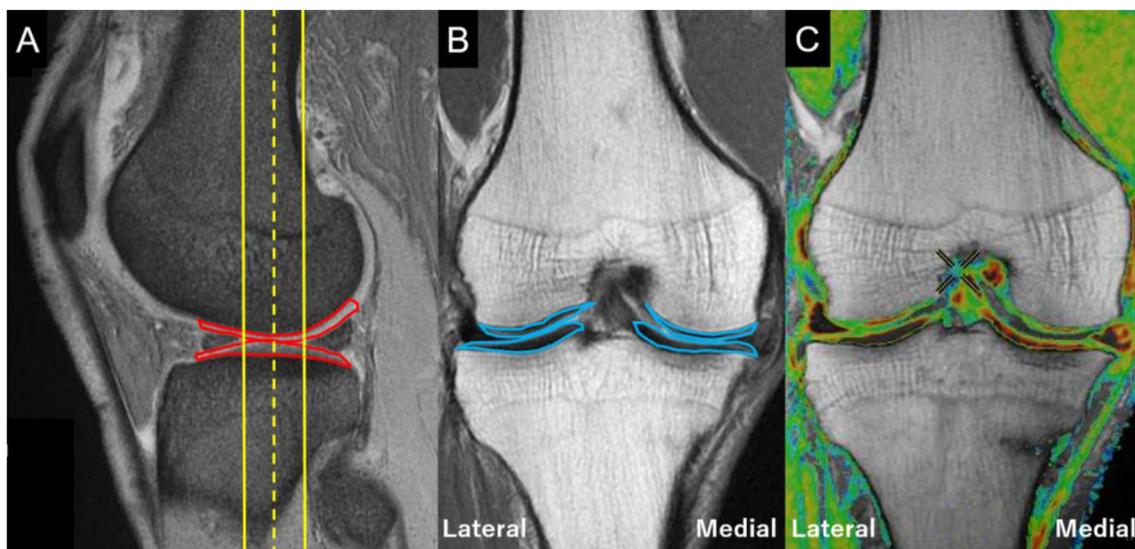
Method of Calculating the T2 Mapping Value of Cartilage. (A) In a sagittal T1-weighted MR image, a central slice (yellow dotted line) was selected to pass through the center of the weight-bearing cartilage (red line), which is positioned between the anterior and posterior margins of the meniscus. Additionally, two adjacent slices were included, located anteriorly and posteriorly to the central slice (yellow solid lines). (B) In the corresponding coronal T2-weighted MR image at the level of the central slice, regions of interest (ROI) were delineated (blue lines) in the cartilage of the medial and lateral femoral condyles, as well as the medial and lateral tibial plateaus. (C) In the coronal T2 map MR image, T2 mapping values were obtained by analyzing the predefined ROI positions. MR: magnetic resonance.
